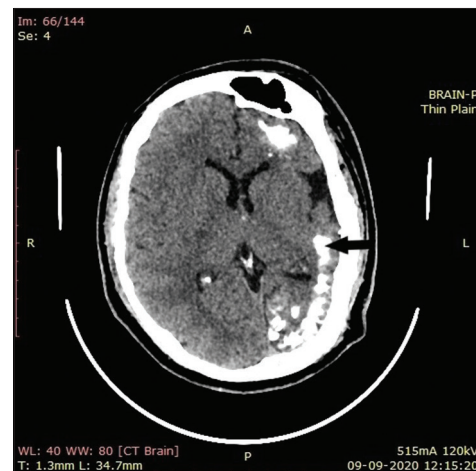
CT brain showed calcifications (arrow) in the left frontal, parietal and occipital lobes and atrophy of left cerebral hemisphere
